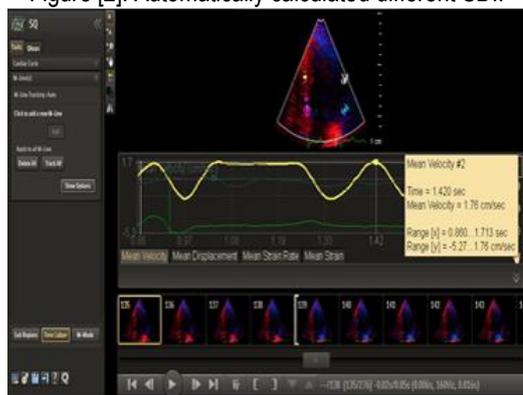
Off-line analysis of the acquired 2-D color DTI images from apical 4-chamber view.
